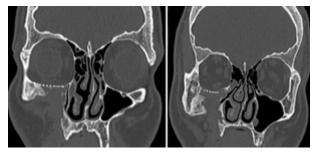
Orbital floor reconstruction with an alloplastic titanium mesh implant. CT of the head (bony windows of the viscerocranium, coronal CT
